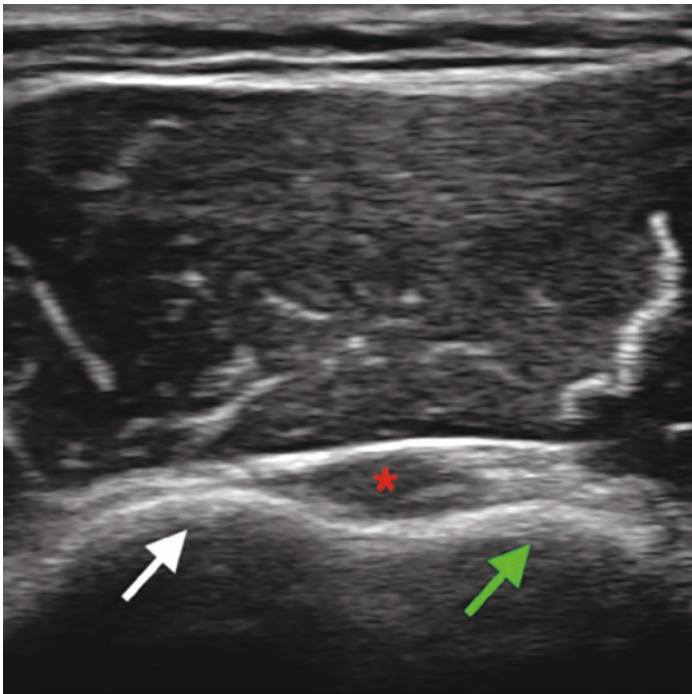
Short-axis ultrasound image showing a normal biceps tendon (red *) sitting within the bicipital groove, which lies between the greater (green arrow) and the lesser tubercle (white arrow) of the humerus
